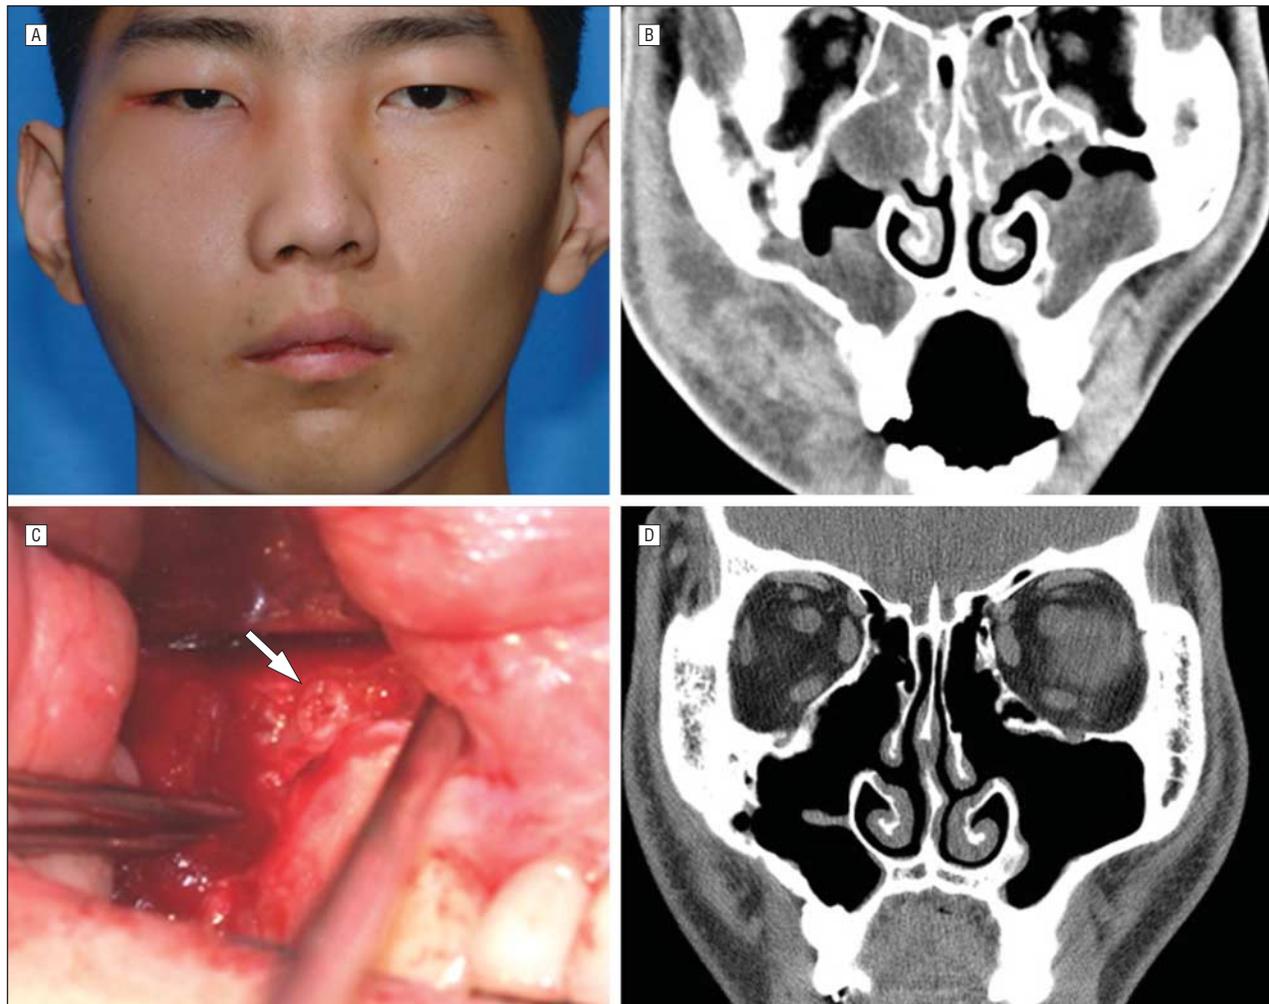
A patient with secondary infection 10 months after surgery. A, A 27-year-old man who underwent surgery using a resorbable plate 10 months earlier; he developed right-sided facial swelling, pain, and tenderness. B, Computed tomography shows pansinusitis and right buccal area abscess formation. C, The resorbable plate and screws (white arrow) were removed, and endoscopic sinus surgery and incisional drainage were performed. D, One month later, the lesions had resolved completely.
